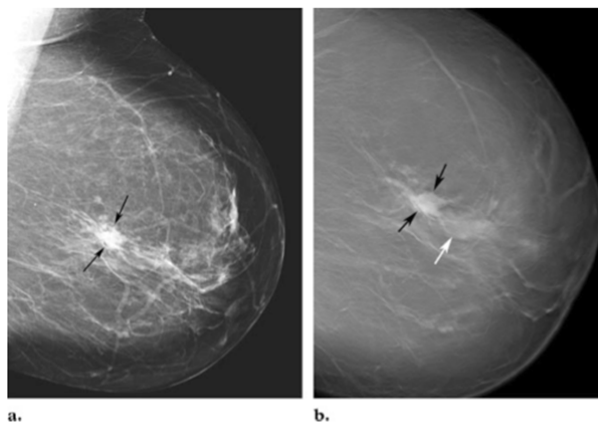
(a) Mammogram and (b) tomosynthesis image of a malignant breast tumor (DCIS). Note the ductal extension of the cancer, seen only on tomosynthesis (white arrow). Reproduced, with permission, from Park JM, Franken EA, Garg M, Fajardo, LL, Niklason, LT. Breast tomosynthesis: Present considerations and future applications. Radiographics, 2007, vol 27 Suppl. 1, pages S231–40.
